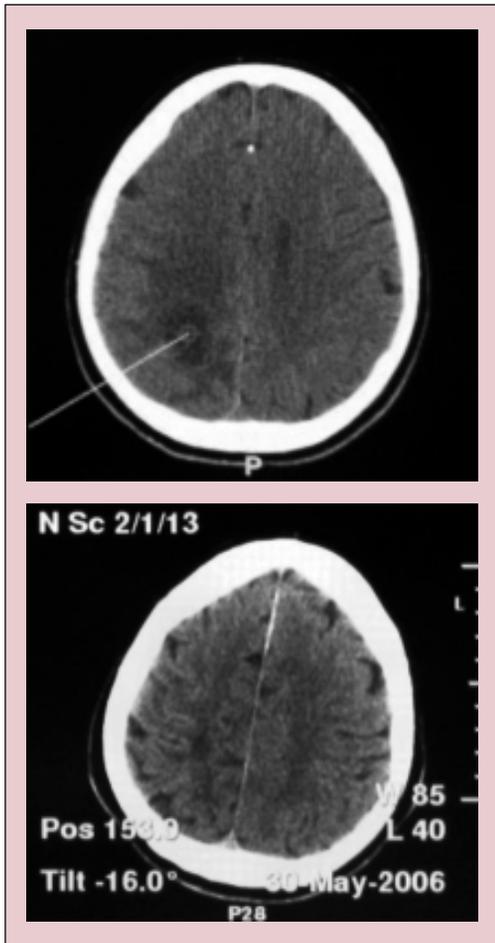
Brain abscess. Up: preoperative CT appearance. Down: postoperative and postantibiotherapy CT appearance.
